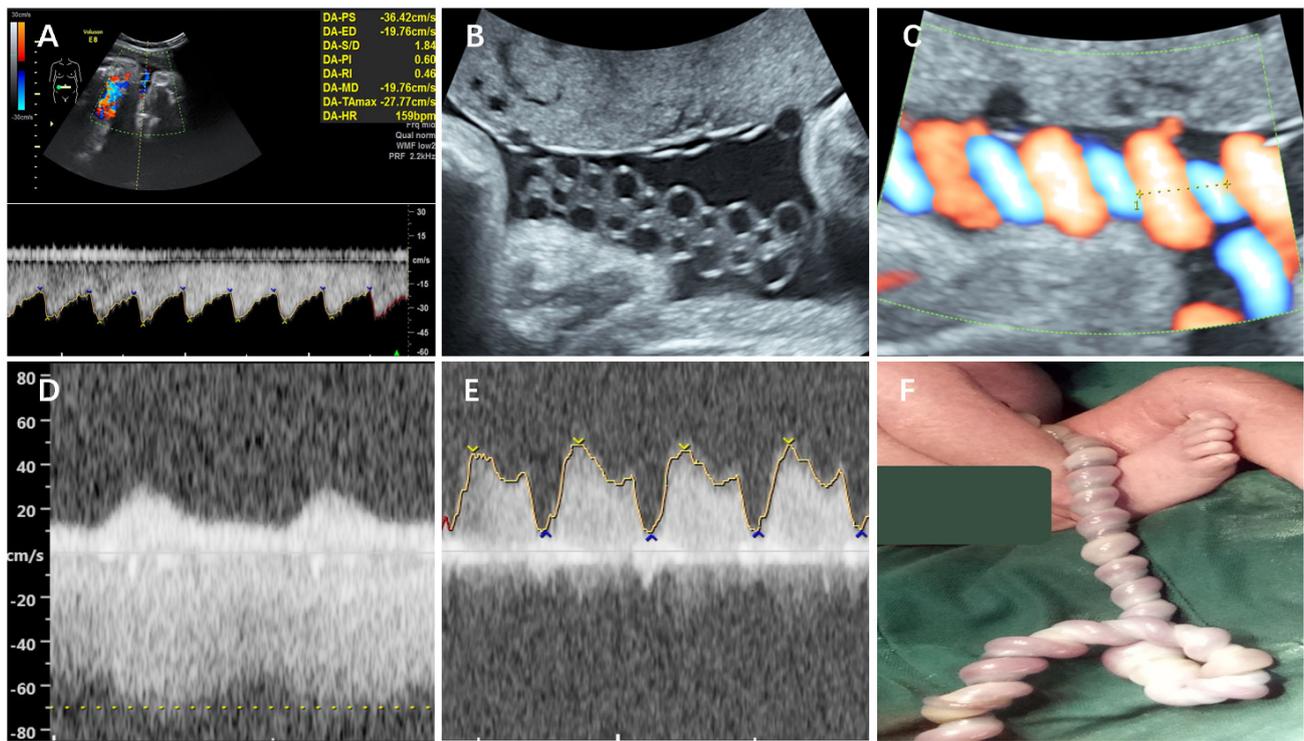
A case of umbilical cord torsion. (A) Abnormal fetal heart monitoring at 32 weeks of gestation, frequency spectrum of umbilical cord free segment. PSV is lower than 5th%, S/D, RI, PI is lower than 10th%. (B) 2D image of high spiral umbilical (changing like chain). (C) Color Doppler image of high spiral umbilical (UCI 0.76). (D) The umbilical vein flow velocity at the umbilical wheel increased (PSV 69 cm/s). (E) Doppler spectrum of intravenous catheter (a notch significantly deepened, PI 1.22). (F) Umbilical cord torsion >30 weeks after birth. UCI, umbilical coiling index.
